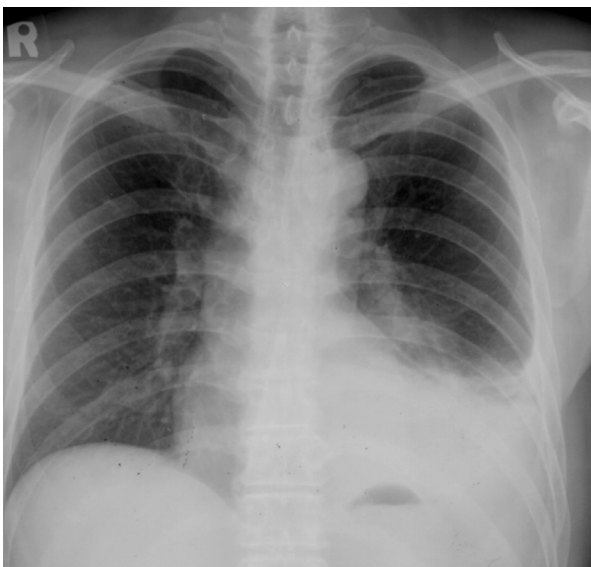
Chest roentgenogram showing a large amount of pleural effusion on the left with passive atelectasis.
